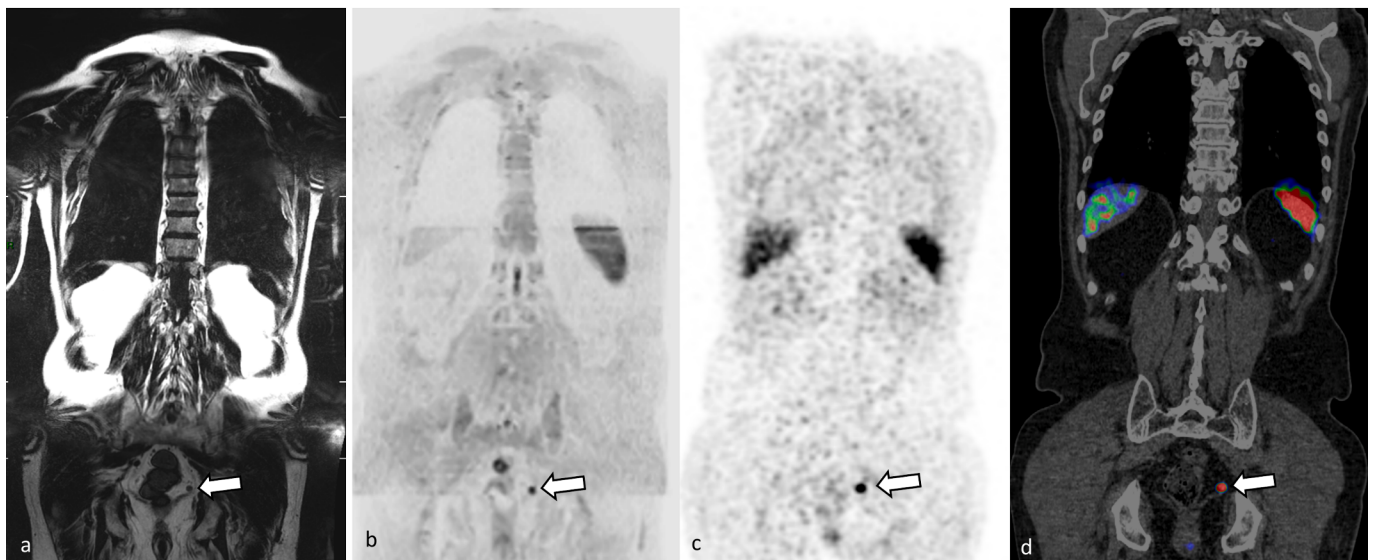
Concordant lymph node staging between fast “All-in-One” WB-MRI and ^{68}Ga -PSMA PET/CT, in a 75-year-old man with high-risk PCa. Panels a-b (fast “All-in-One” WB-MRI) show coronal WB-MRI T1 Dixon fat only (a), and coronal reformatted DWIBS ($b = 1000 \text{ s/mm}^2$; inverted grey scale) images showed a left 8 mm mesorectal lymph node metastasis (arrow) (b). Panels c-d (^{68}Ga -PSMA-PET/CT) show coronal metabolic PET (c), and coronal reformatted fused PET/CT images showed the same lymph node metastasis with PSMA expression (arrow) (d).
